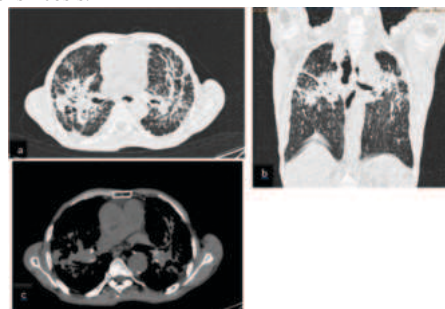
Axial(a) and coronal(b) section of lung window and axial section of mediastinal window (c) of HRCT showing extensive areas of perihilar consolidation, fibrosis, volume loss, and architectural distortion. Numerous fine nodules throughout both lungs and calcified mediastinal and hilar lymph nodes.
